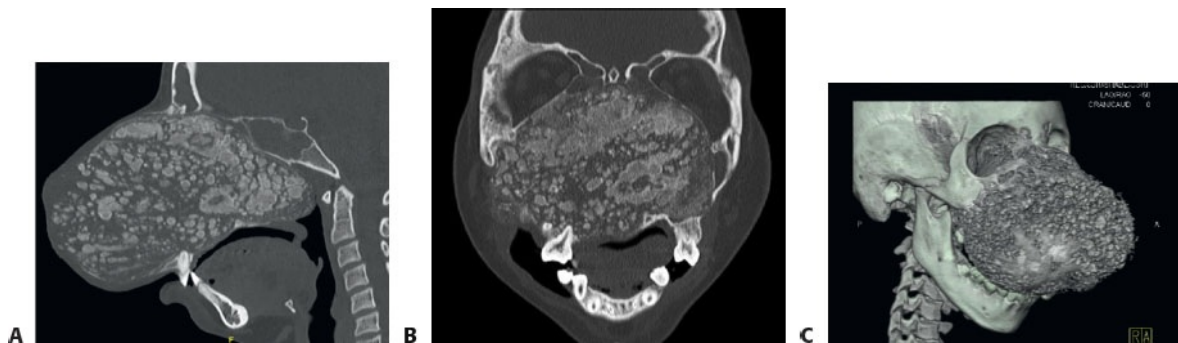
• CT scan of patient with large lower zone 1 fibrous dysplasia. A. Sagittal cut. B. Coronal cut. C. 3D reconstruction.
